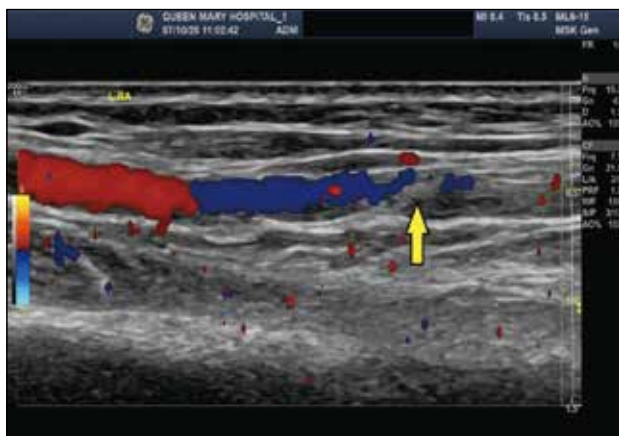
Colour Doppler ultrasound showed partial radial artery occlusion (arrow) at the puncture site.
